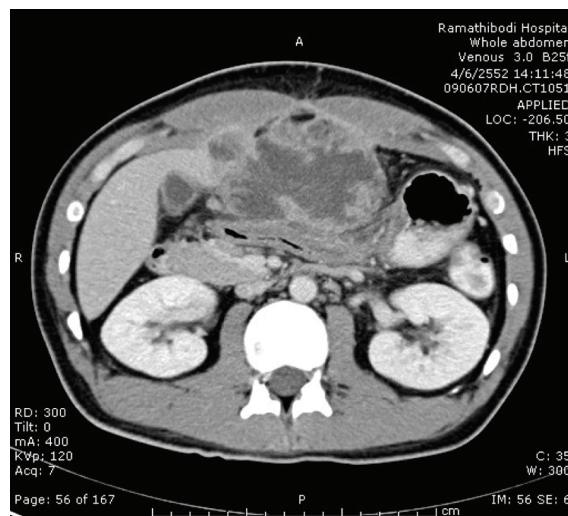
CT scan showing a large exophytic solid mass, size $6.2 \times 6.2 \times 4.7$ cm, arising from anterior wall of gastric body with perforation
